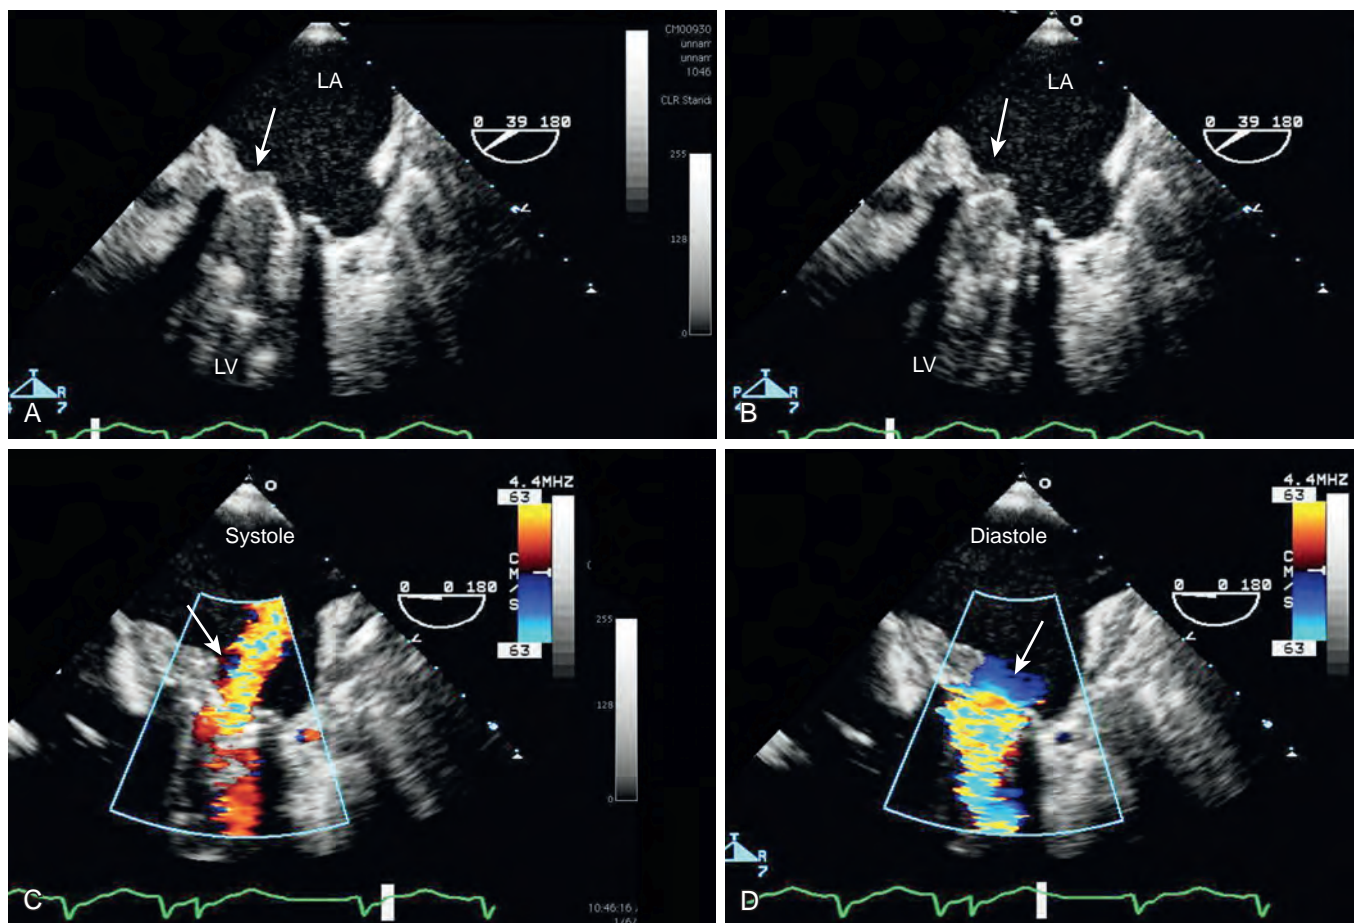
After mechanical mitral valve replacement: stuck leaflet: thrombus. Stuck mechanical leaflet of a bileaflet mechanical valve in the mitral position, probably the result of thrombus. The medial leaflet (white arrow) appears to be stuck in a closed position and surrounded by thickening consistent with thrombus formation shown in (A) systole and (B) diastole. Color Doppler imaging demonstrates turbulent flow consistent with both (C) regurgitation and (D) stenosis. LA, Left atrium; LV, left ventricle.
